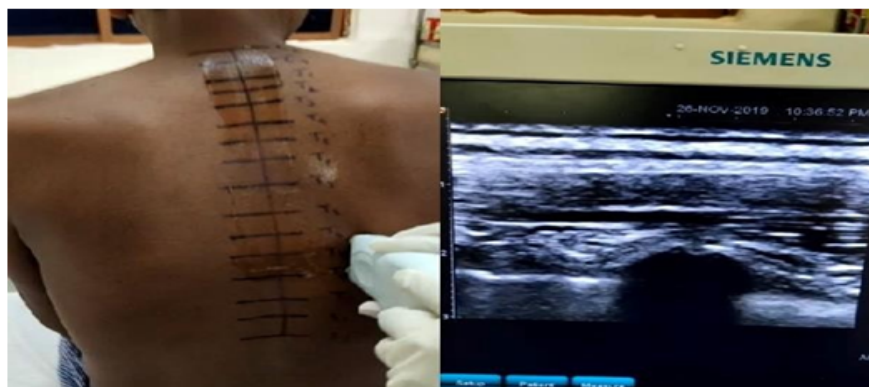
Surface and ultrasound anatomy of erector spinae plane muscles at T10 vertebral level.
